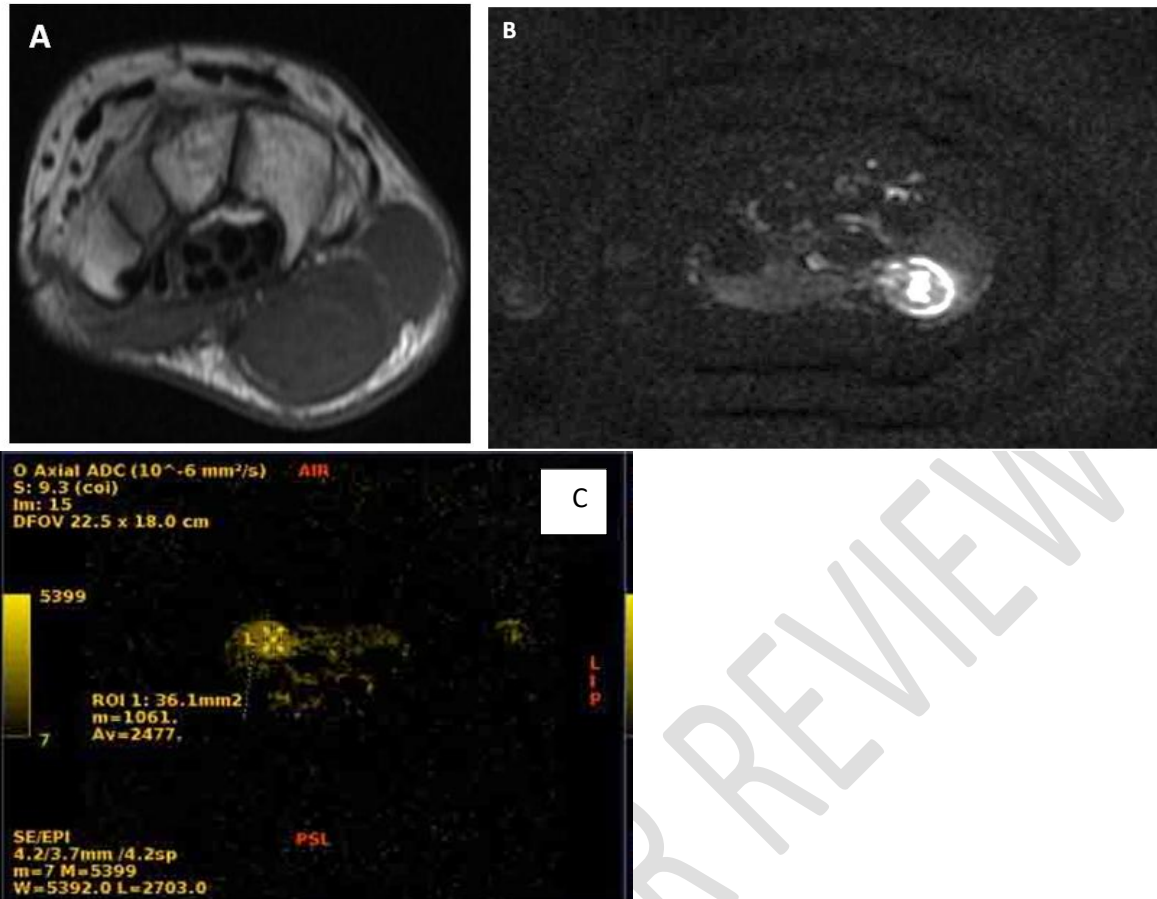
(A) Axial T1, (B) axial DWI, (C) ADC showing well defined subcutaneous soft tissue lesion seen at hypothenar eminence of the right hand.
